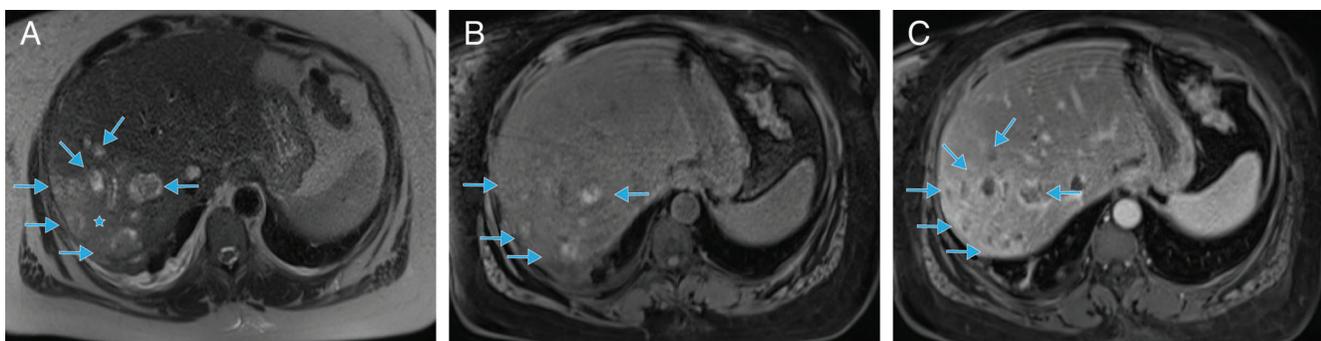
Magnetic resonance imaging (MRI). A. T2-weighted image demonstrates multiple (at least six) small hyperintense abscess cavities in the right hepatic lobe (blue arrows). Note the hyperintense, edematous hepatic parenchyma (blue star). B. Noncontrast T1-weighted fat-sat image demonstrates varying degrees of T1 hyperintensity in the abscess cavities consistent with proteinaceous debris. C. Postcontrast T1-weighted fat-sat image demonstrates peripheral or rim enhancement around each of the abscesses.
